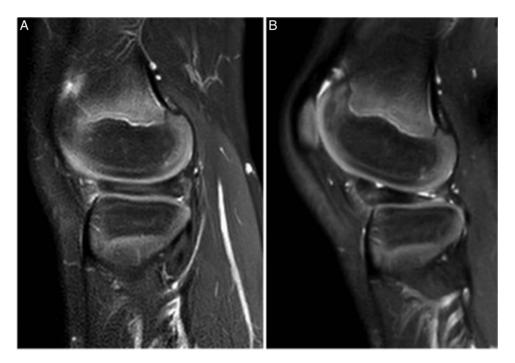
Case no. 7. MRI (T2 FS, sagittal) acquisition of a left knee during the dynamic protocol, revealing a reduced meniscus after the "clock" (A) and an anteriorly dislocated meniscus after the "pop" (B). Arthroscopy confirmed a posterior peripheral meniscal detachment (MC-P type). A, MRI (T2 FS, sagittal) performed after the "clock," showing posterior displacement of the meniscus. B, MRI (T2 FS, sagittal) performed after the "pop," showing the meniscus without displacement in the sagittal plane. FS indicates Fat-Sat; MRI, magnetic resonance imaging.
